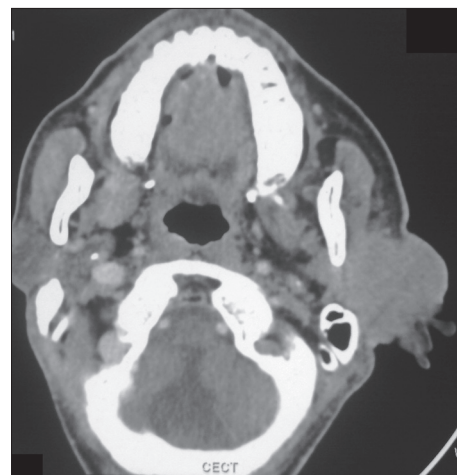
Represents the computed tomography of a patient with salivary duct carcinoma which shows a mass arising from the left parotid gland infiltrating the deep lobe and the masseter muscle
